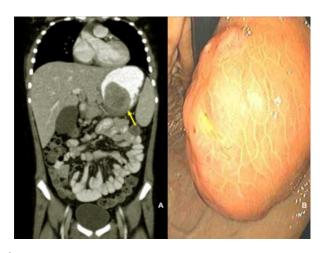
Abdominal CT(A) and esophagoduodenoscopy (B) showing a large mass extending intraluminally from the posterior wall of the body of the stomach.
